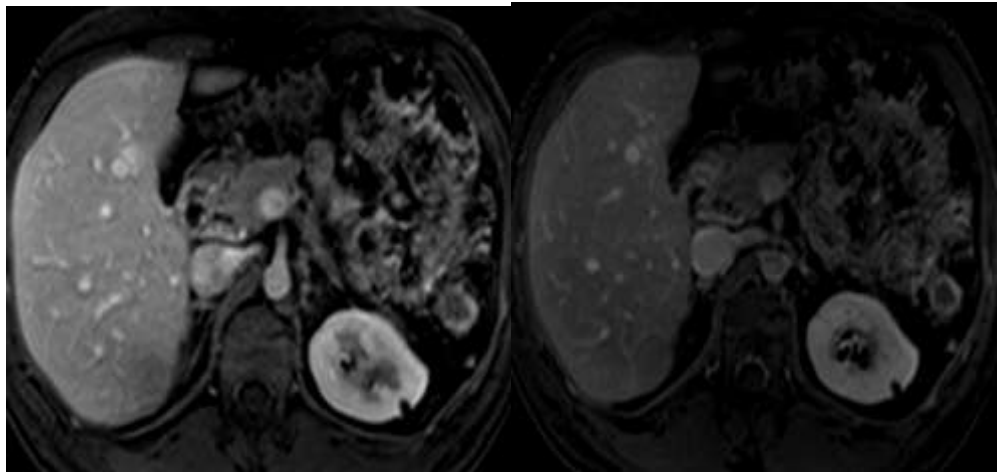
MRI postcontrast venous and delayed phase imaging shows mild washout
